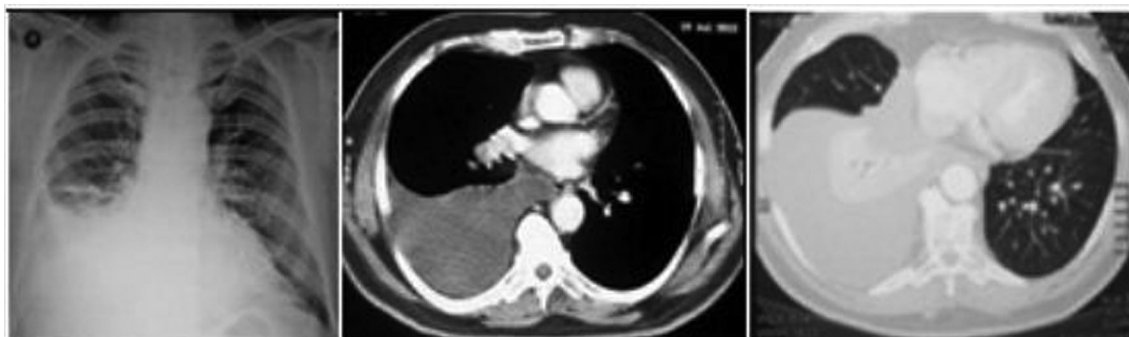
Chest X-ray and computed tomography (CT) of the patient showing right-sided pleural effusion with collapse of right lower lobe.
